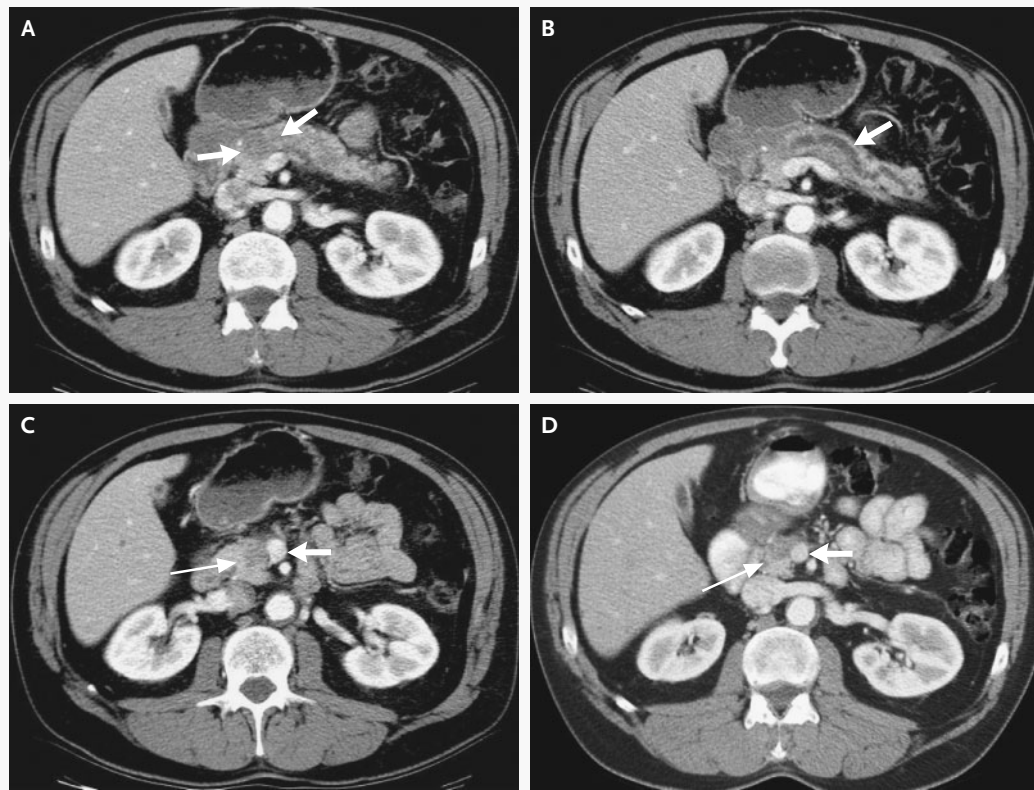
Axial Contrast-Enhanced CT Images through the Pancreas.
